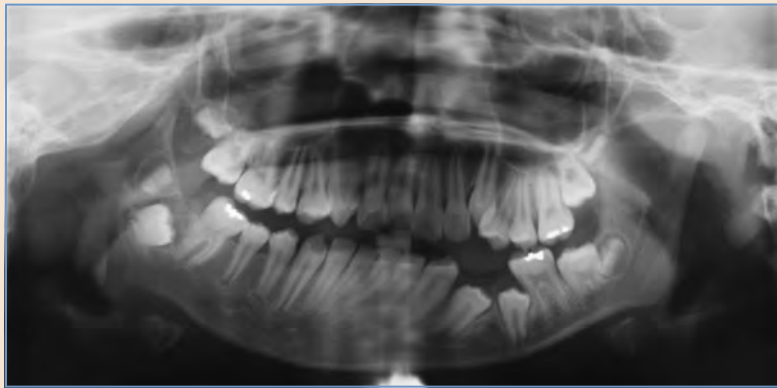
An ortho-Panorex radiograph shows the dental crowding and crossbite that accompany a hypoplastic mandible.
